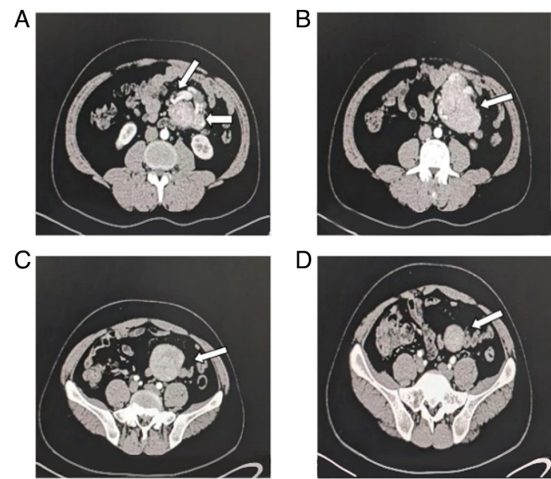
Relationship between tumors and mesenteric vessels (arrows indicate mesenteric vessels). (A) Enhanced computed tomography shows that the huge mass originates from the starting point of the mesenteric vessels, arterial enhancement of the mass, and feeding vessel. (B) The mass is surrounded by large mesenteric blood vessels and the boundary is unclear. (C) Relatively isolated location of mass. (D) The lowest boundary of the mass.
